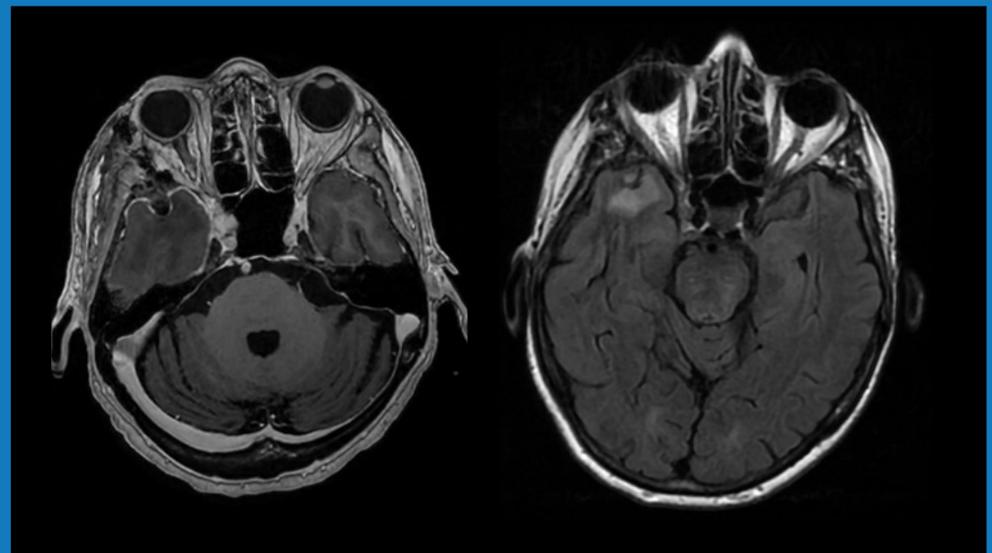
(Left) Postoperative axial T1-weighted MRI with gadolinium demonstrating complete resection of the middle fossa lesion. (Right) Axial FLAIR MRI showing significant improvement in peritumoral vasogenic edema.
